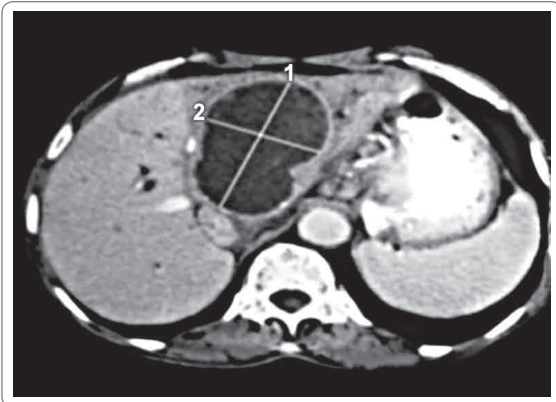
CT scan shows a large noncalcified hydatid cyst in right hepatic lobe (Courtesy: Dr. Soma Sarkar)
